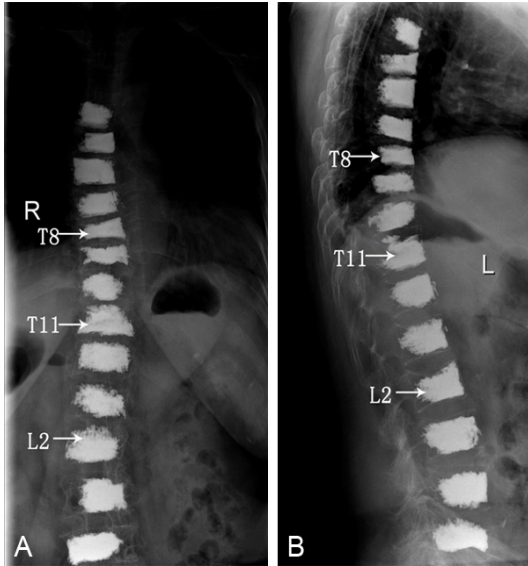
Postoperative AP (A) and lateral (B) view by X-ray.
